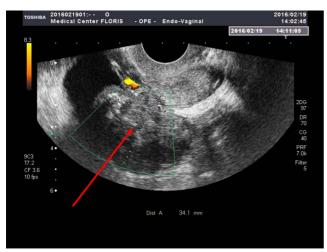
Ultrasound investigation of female genitals. Arrow shows the tumor
